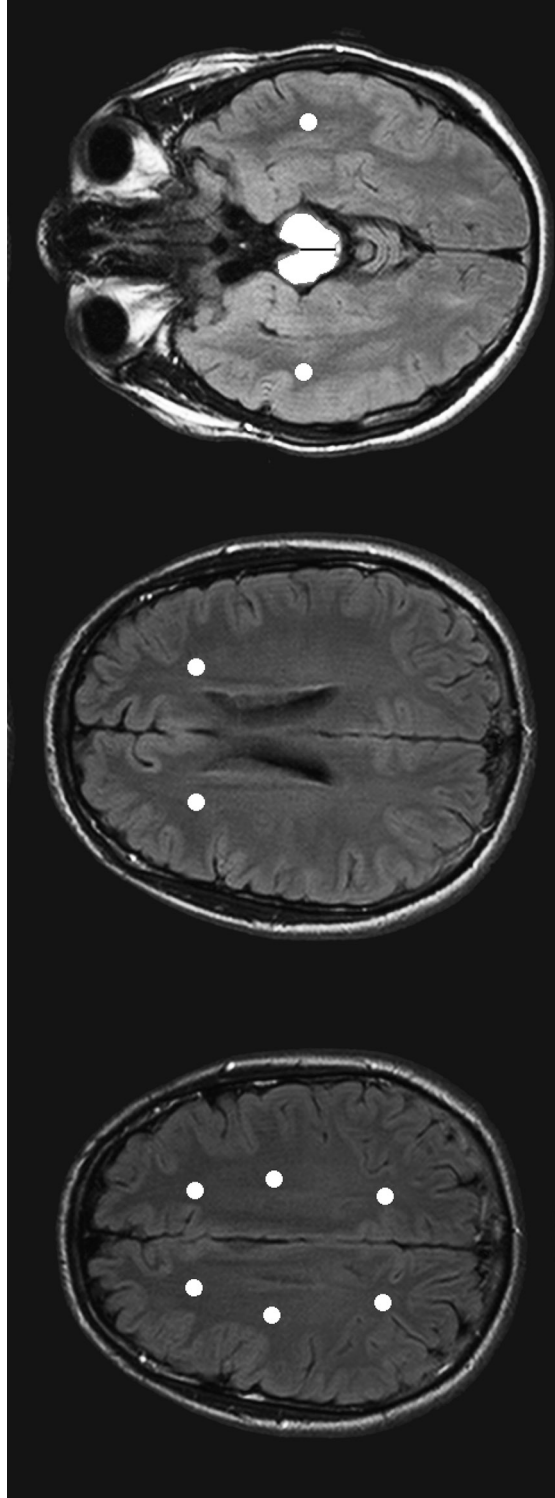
Axial FLAIR image slices on selected anatomical levels from left to right: centrum semiovale, corona radiata and mesencephalon. ROIs have been drawn in the images.
